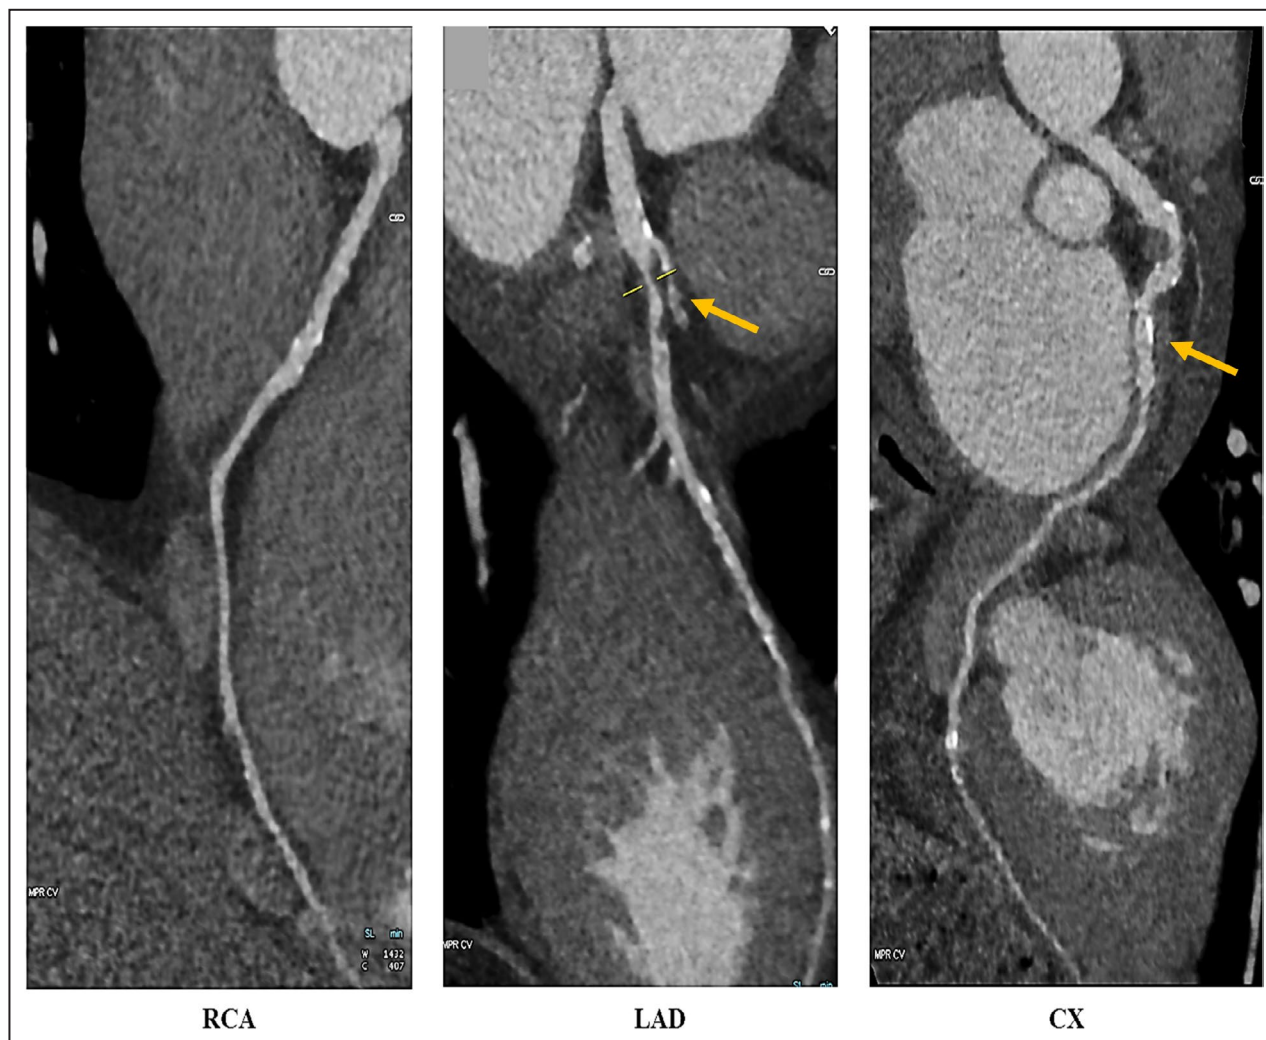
Coronary CT angiogram of a 44-year-old male study participant showing varying degrees of atherosclerosis in the coronary arteries.
